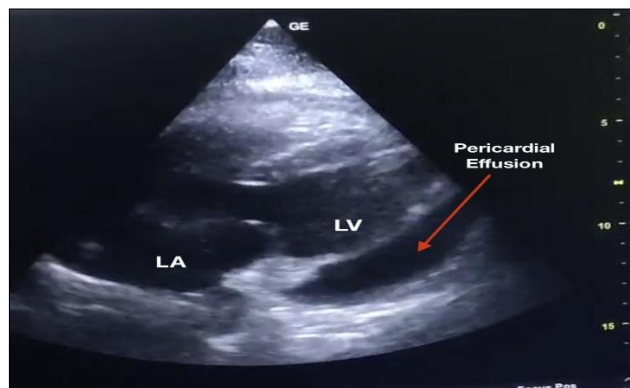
2D Echocardiography showing pericardial effusion with swinging heart motion.
